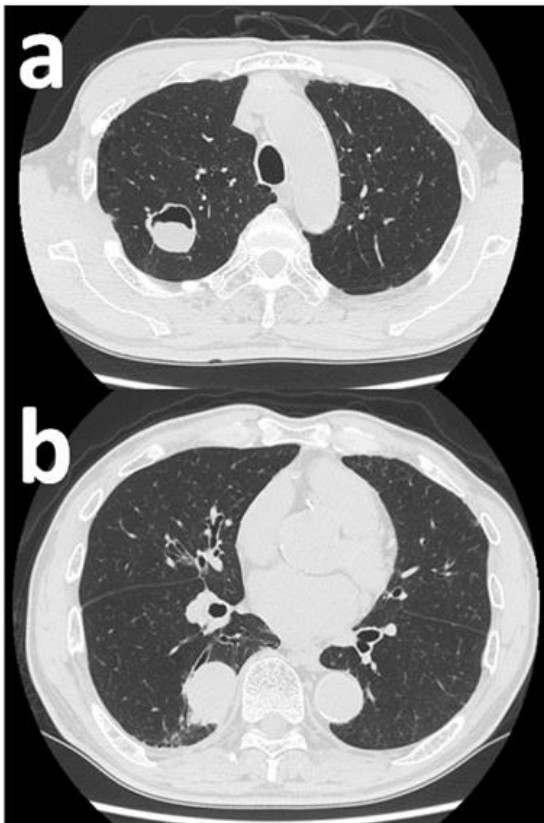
Lesions were detected in the right upper lobe (a) and lower lobe (b) on chest CT. Each lesion was subsequently confirmed as squamous cell carcinoma on preoperative bronchoscopy.
